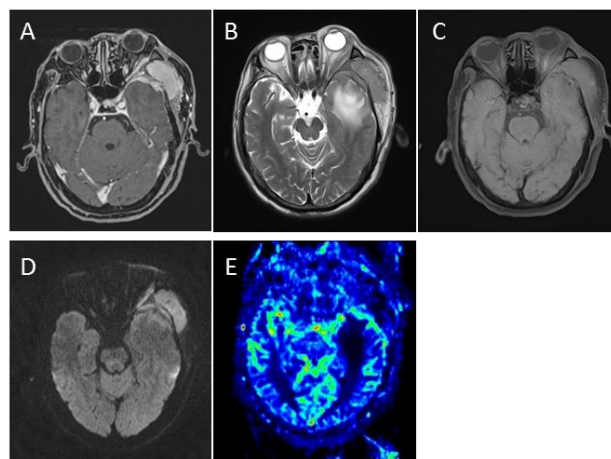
A) T2WI image; B) T1WI image; C) DWI image; D) T1-contrast enhancement image; E) PWI image.
